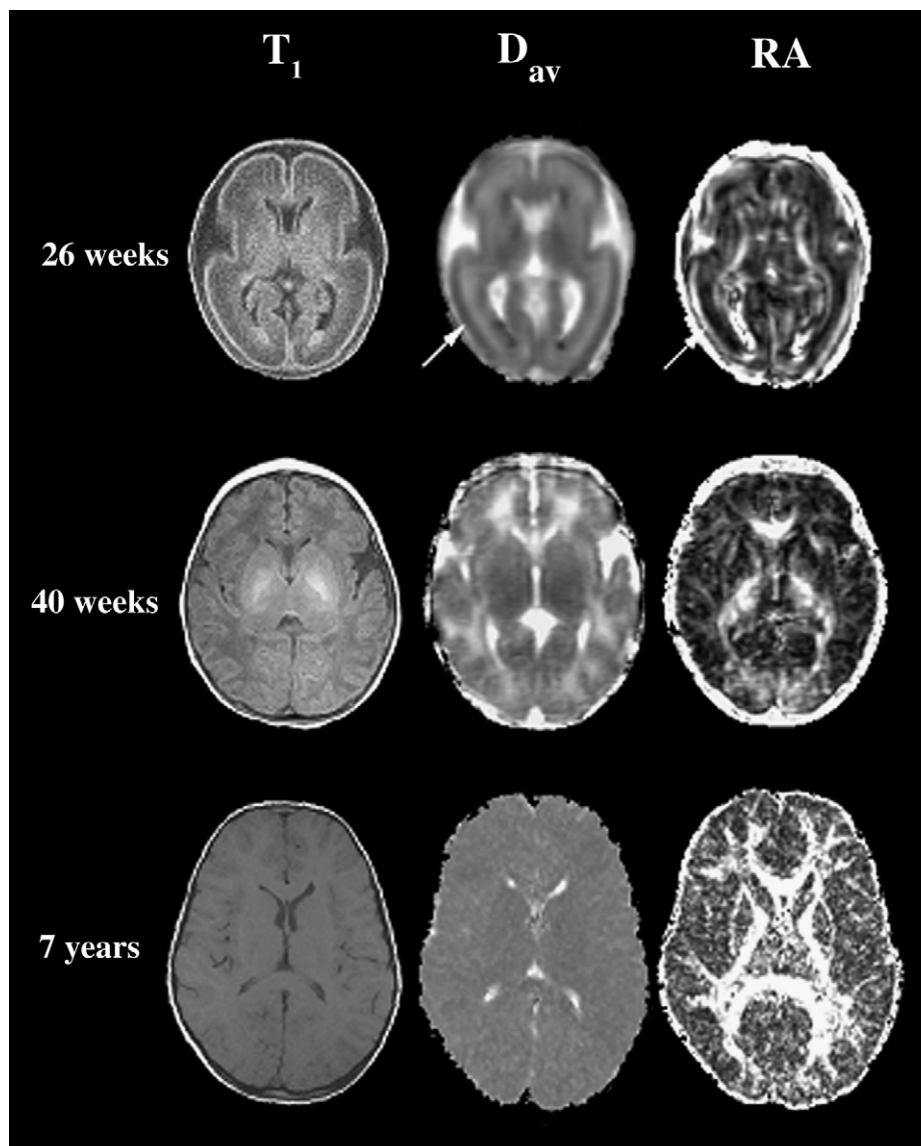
Axial images at the level of the basal ganglia from subjects of different ages. The top row is from a premature infant of 26 weeks' gestational age. The middle row is from a term infant of 40 weeks' gestational age. The bottom row is from a 7-year-old child. All three subjects were normal at the time of the study. The left column consists of T1-weighted images for anatomic reference. The center column consists of D_{av} parametric maps for which higher values of D_{av} appear brighter. The right column consists of relative anisotropy (RA) parametric maps for which higher values of RA appear brighter.² From Neil et al. (2002, *NMR Biomed* 15:543–552) with permission.
